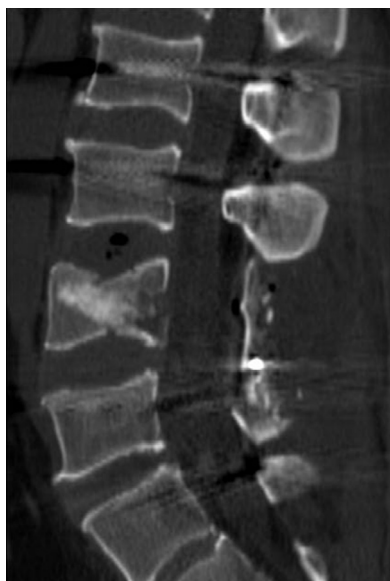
The postoperative CT scan shows satisfactory reduction of dislocation and the cleft of the L4 vertebral body filled with autogenous iliac bone.
